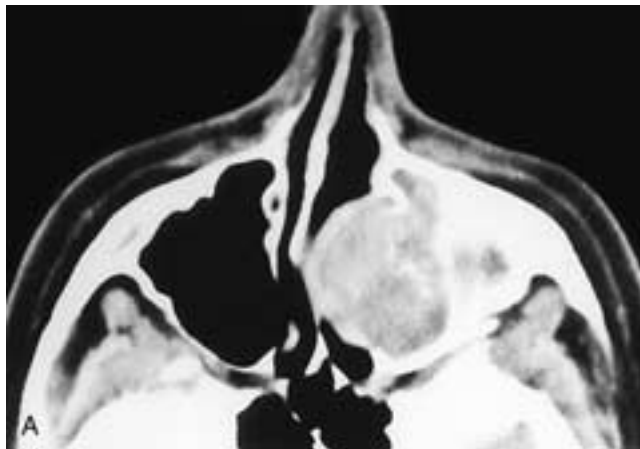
Axial CT scan (A) shows a soft-tissue mass in the left maxillary sinus that has thickened the posterior bony wall and thinned or destroyed the medial wall. Within the mass are several discrete calcifications. This patient had aspergillosis. Coronal CT scan (B) on a different patient shows soft-tissue disease in both ethmoid and maxillary sinuses and within both nasal fossae. In addition, there are calcifications in the nasal septum. This patient had aspergillosis.
